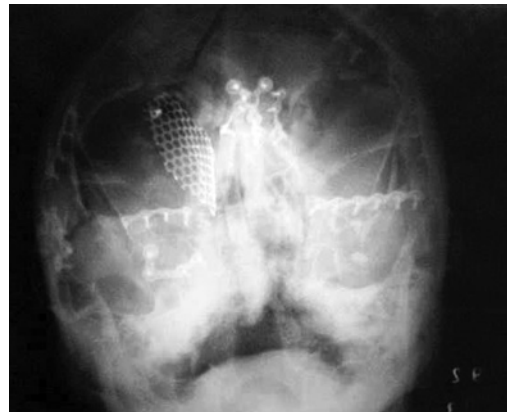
Post-operative conventional x-ray showing nasoethmoidal fracture correction, associated to additional middle third fractures: reconstruction with bone grafts, titanium mesh, microplates and screws.
